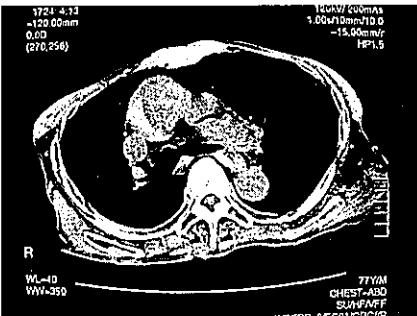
Autopsy imaging, CT, slice #13
